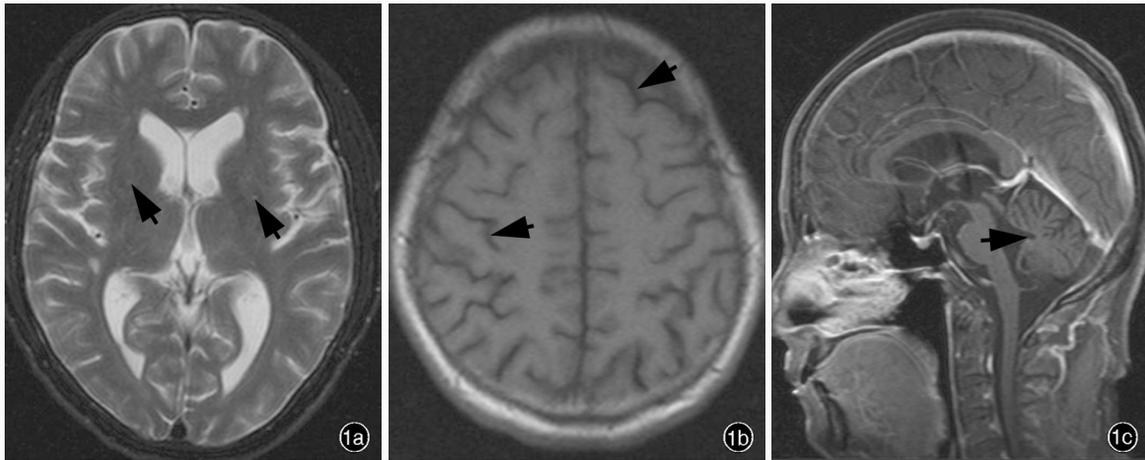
头部 MRI 检查所见 1a 横断面 T₂WI 显示基底节区多发性高信号(箭头所示),提示多发性脑梗死灶 1b 横断面 T₁WI 显示脑沟加深(箭头所示) 1c 矢状位 T₁WI 显示小脑脑沟增宽,提示小脑萎缩(箭头所示)
